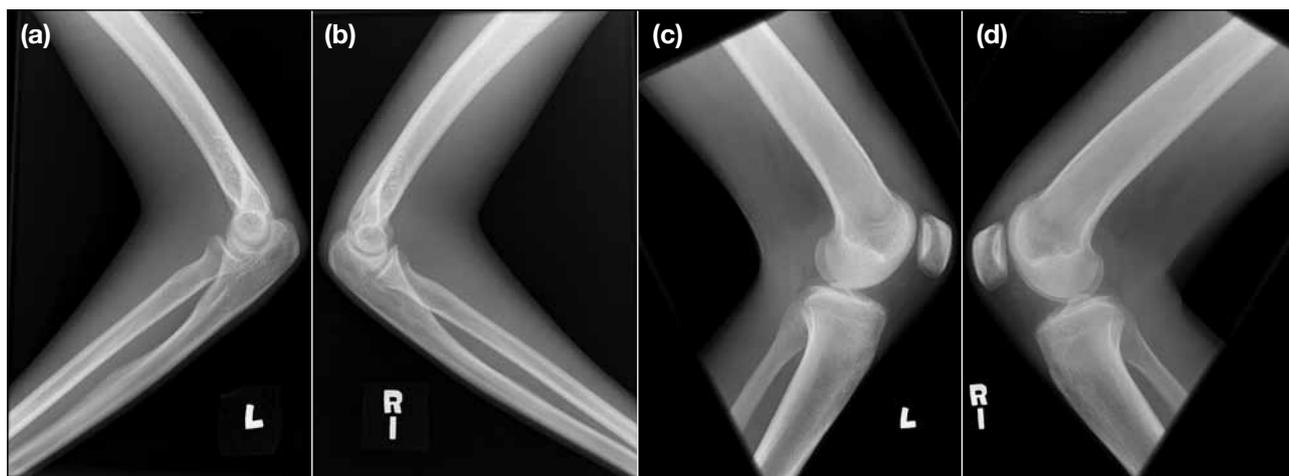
Bilateral flexion contractures are noted in both elbows and knees. Lateral radiographs of (a and b) bilateral elbows and (c and d) knees show symmetrical decreases in muscle bulk and reveal no bony abnormality.
